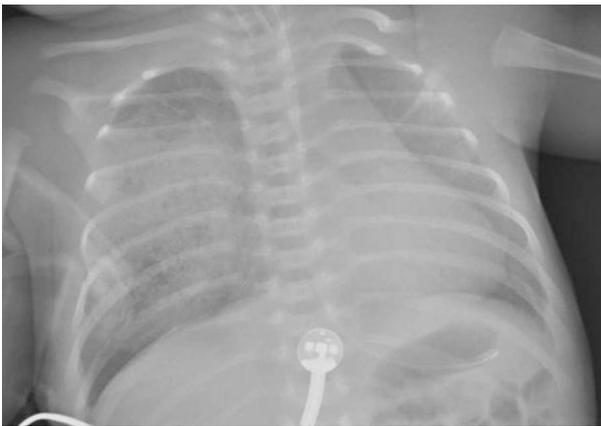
First days chest radiograph; multiple small cystic filled with air in the middle lobe of the lung and the heart was pushed to left of chest
